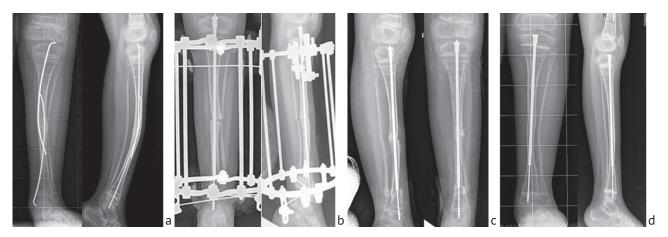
An instance of revision correction of tibial deformity showing (a) preoperative radiographs; (b) combined osteosynthesis with the Ilizarov apparatus and titanium nail; (c) external fixation devices removed; (d) rod telescoping and no signs of migration at 12-month follow-up
